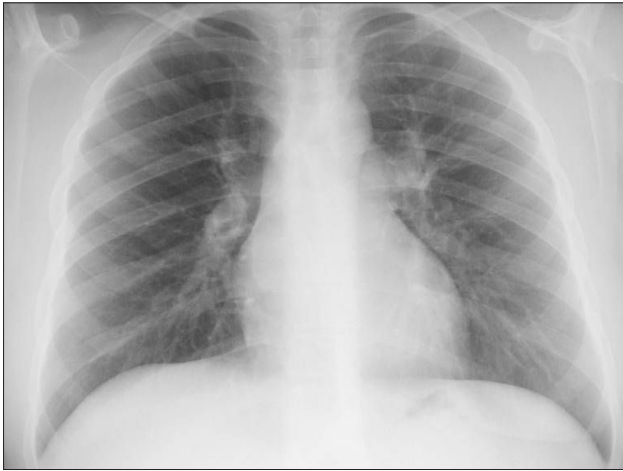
Normal chest X-ray of patient
